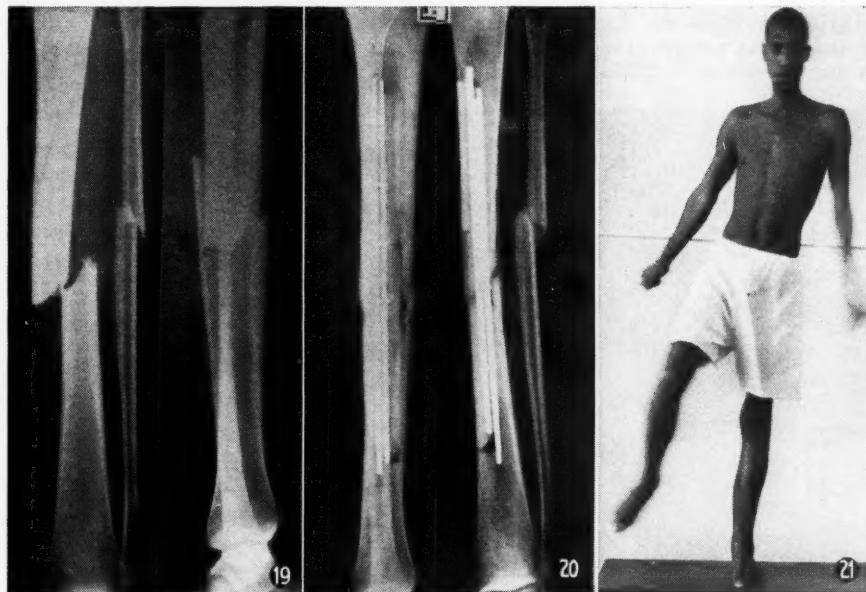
Case No. 3. X-ray of original injury.
